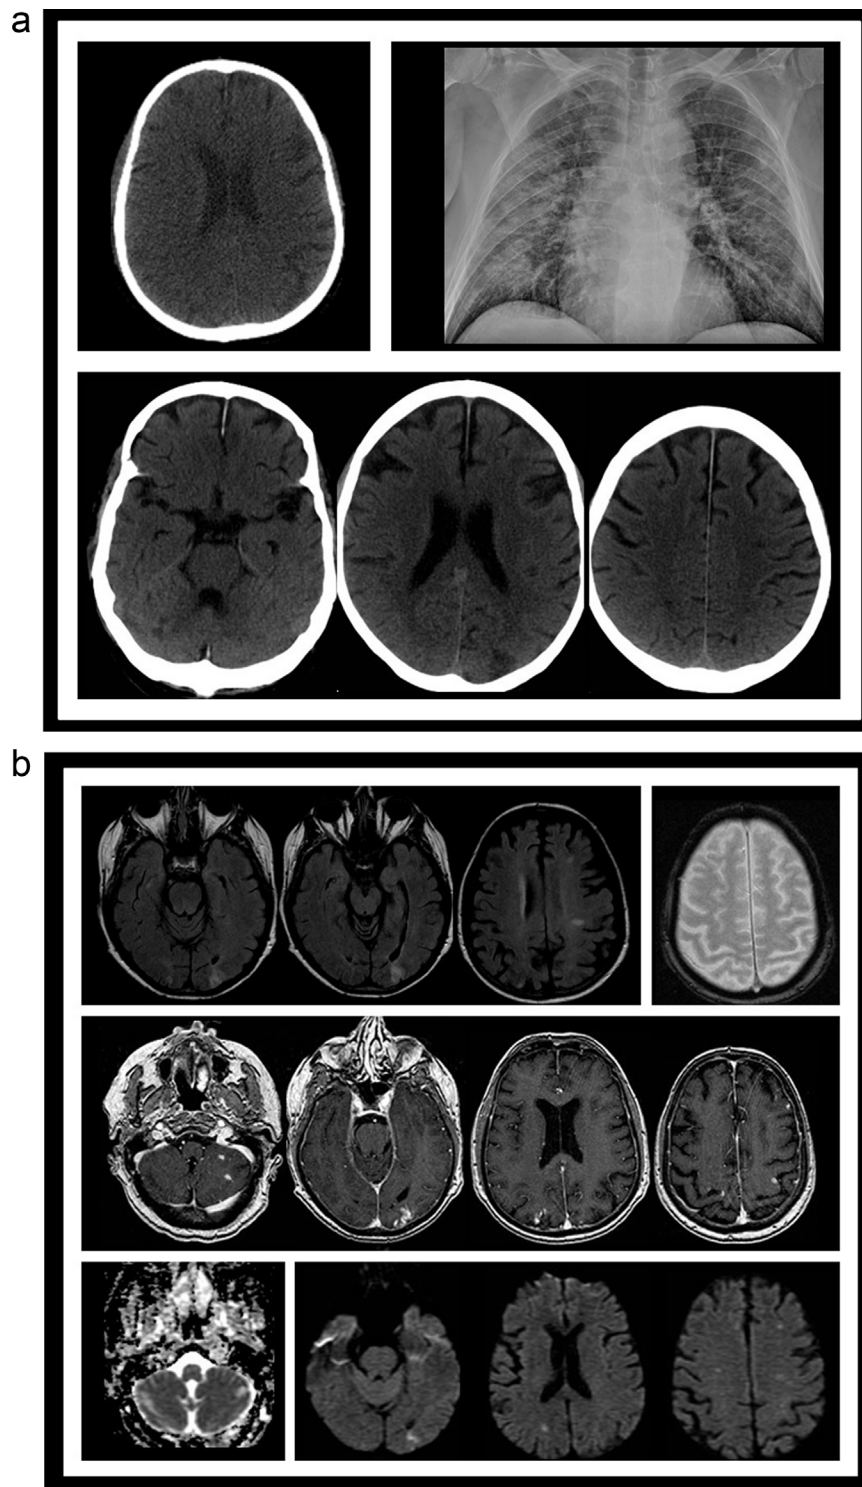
(a) CT image (A) from PET/CT scan evaluation for the light-chain disease showing no abnormality ten days before the onset of fever. Chest RX (B) showing bilateral lung infiltrates. Different slices from head CT (C) obtained after the patient developed neurological symptoms demonstrating several low attenuating lesions (arrows), both cortical and white matter locations. (b) Different sequences from a MRI study obtained a week after the start of the neurological symptoms. FLAIR slices (A), gradient-echo (B), postgadolinium injection 3D FSPGR T1-weighted slices (C), ADC map (D) and diffusion-weighted slices, showing several subacute small infarcts (arrows), with high signal in both T2 and DWI images, contrast enhancement, and decreased ADC values in some of them.
